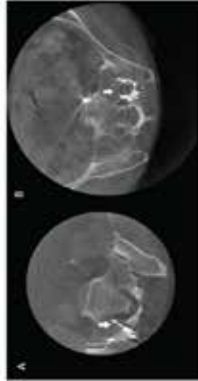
A, Axial 3D-CBCT image of the S1 nerve root compartment showing contrast spread from the sacroiliac joint. B, Axial 3D-CBCT image of the S1 nerve root compartment showing localized contrast spread within the sacroiliac joint.
